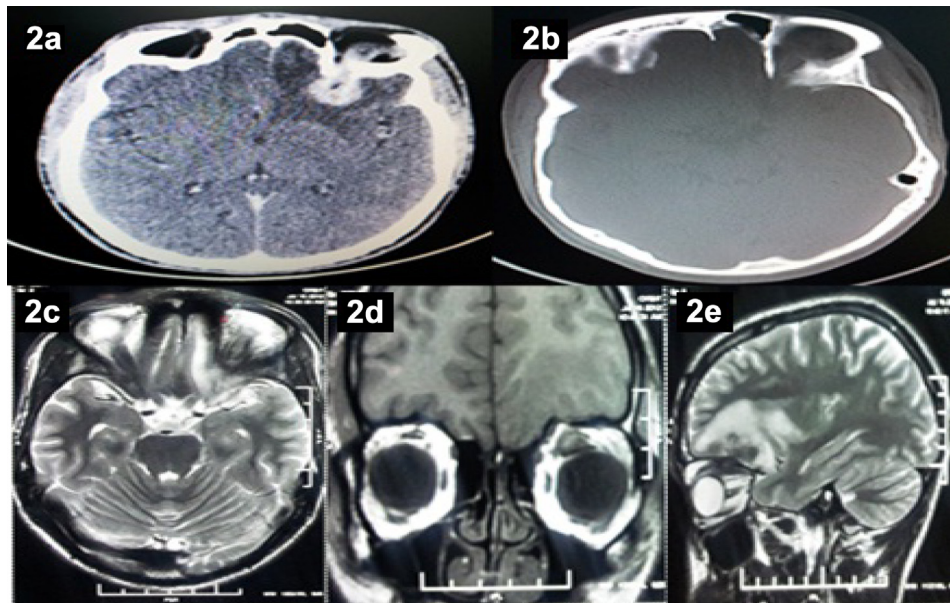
(a) CECT head showing contrast enhancing lesion extending from left orbital roof fracture to left basifrontal region with perilesional edema, (b) showing bone window of skull with blowout fracture and defect in left medial orbital roof. (c) MRI of same patient axial-section (T2WI), (d) coronal-section (T1WI) and (e) sagittal sections (T2WI) showing foreign body in left orbit involving superior rectus muscle and extending through orbital roof into left basifrontal region causing perilesional edema.
